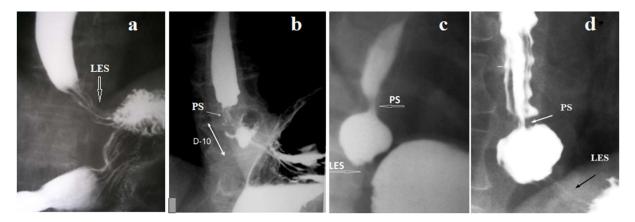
Radiographs of EGJ in patients with GERD. Each image shows longitudinal folds at the LES level (between the esophagus and stomach). Contraction of the proximal sphincter (PS), which blocks the lumen of the esophagus above the phrenic ampulla, provides high pressure in the ampulla, which injects the bolus into the stomach.
